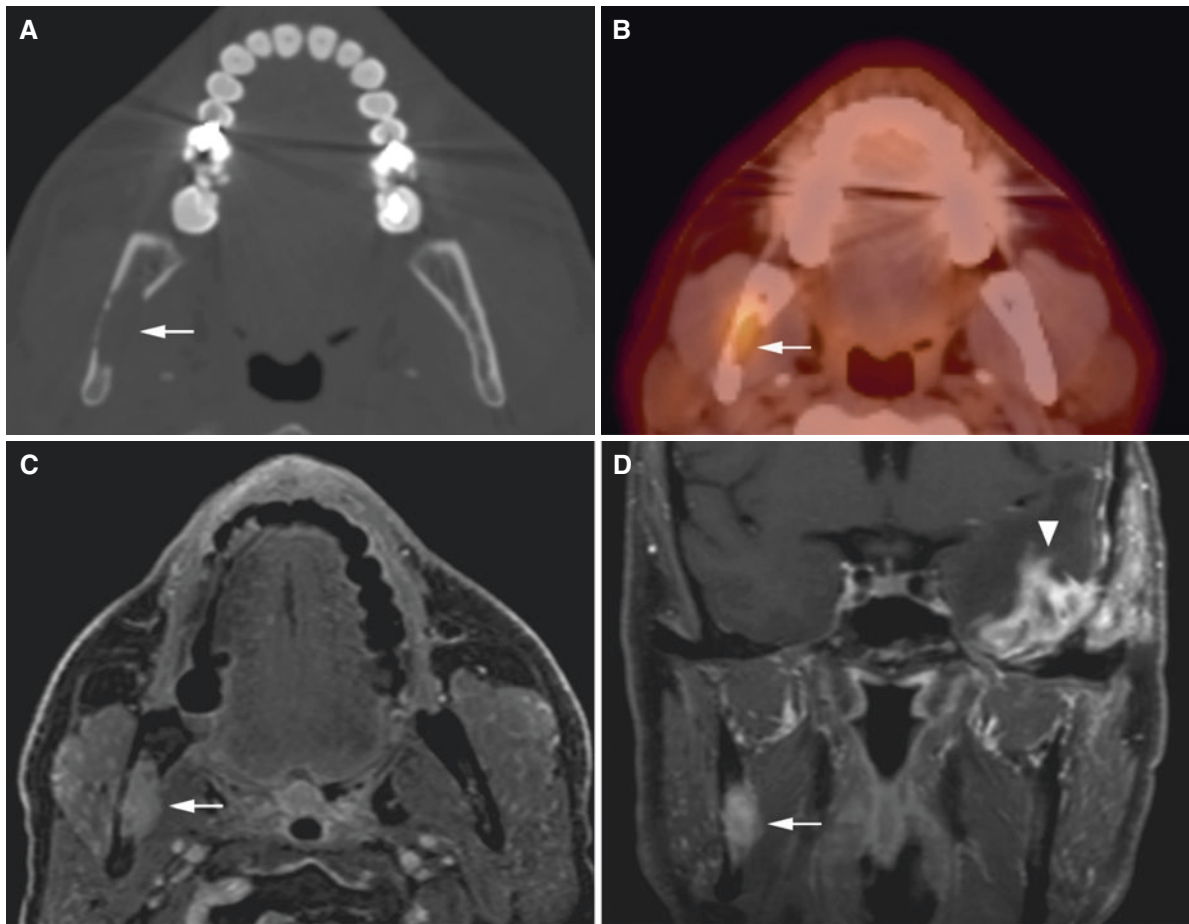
Anaplastic malignant meningioma metastasis, mandible; 56-year-old male with pain (6 on a scale 1–10) under his lip and extending across the right lower cheek. (A) Axial CT image shows destruction of right lingual mandibular foramen (*arrow*). (B) Axial PET-CT image
